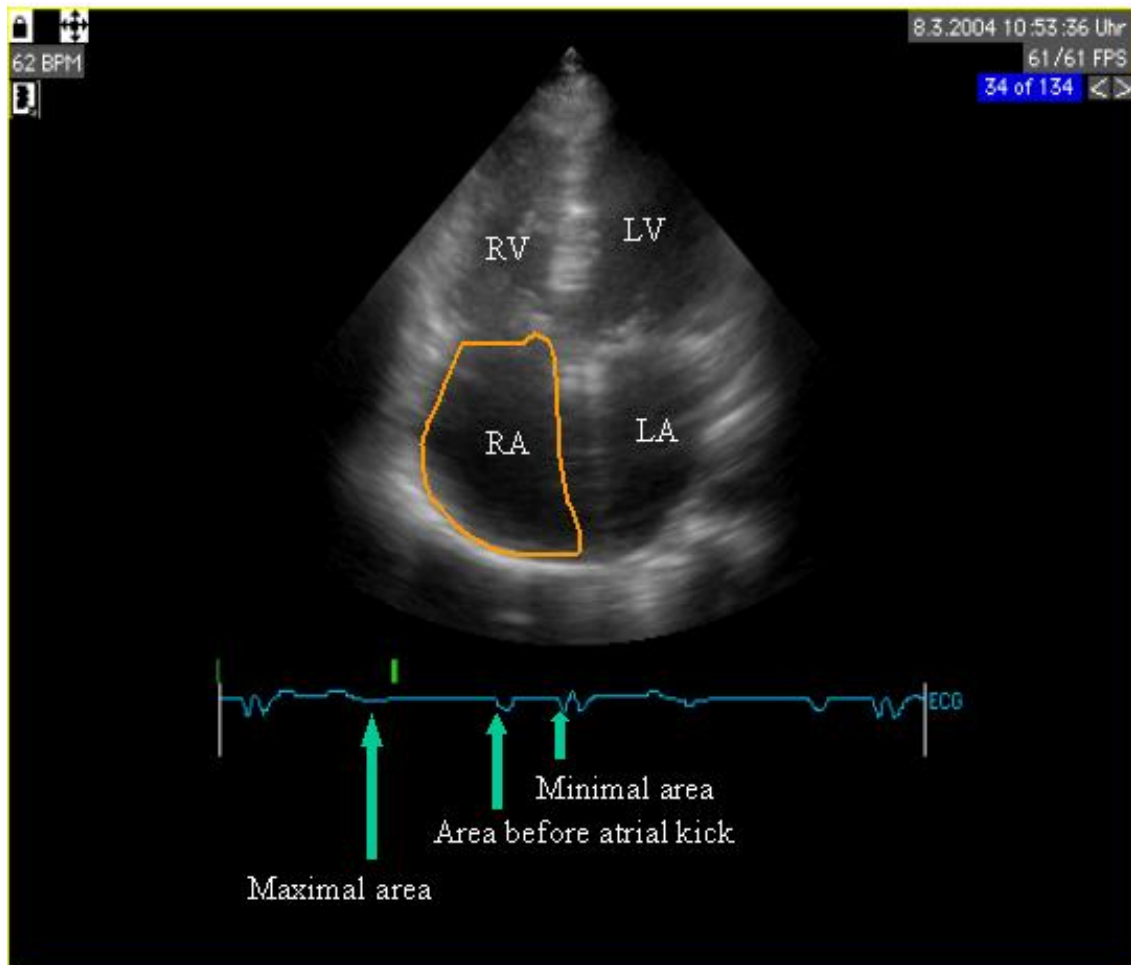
Method applied in measuring the right atrial areas from echocardiographic apical four chamber view. Right atrial areas were measured when the atrium reaches maximum, onset of atrial contraction and minimum.
